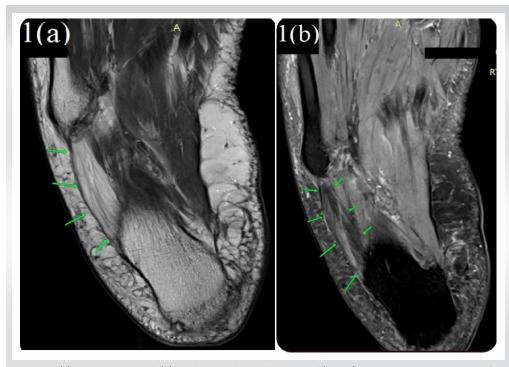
(a) Axial T2 weighted, (b) axial proton density fat saturated (PDFS) magnetic resonance images of the sole show severe atrophy and fatty infiltration selectively involving the abductor digiti minimi muscle belly, representing chronic Baxter's nerve impingement (green arrows). Note that the signal intensity of the abductor inferior calcaneal impingement digiti minimi is similar to that of adjacent subcutaneous fat with no muscle edema.
